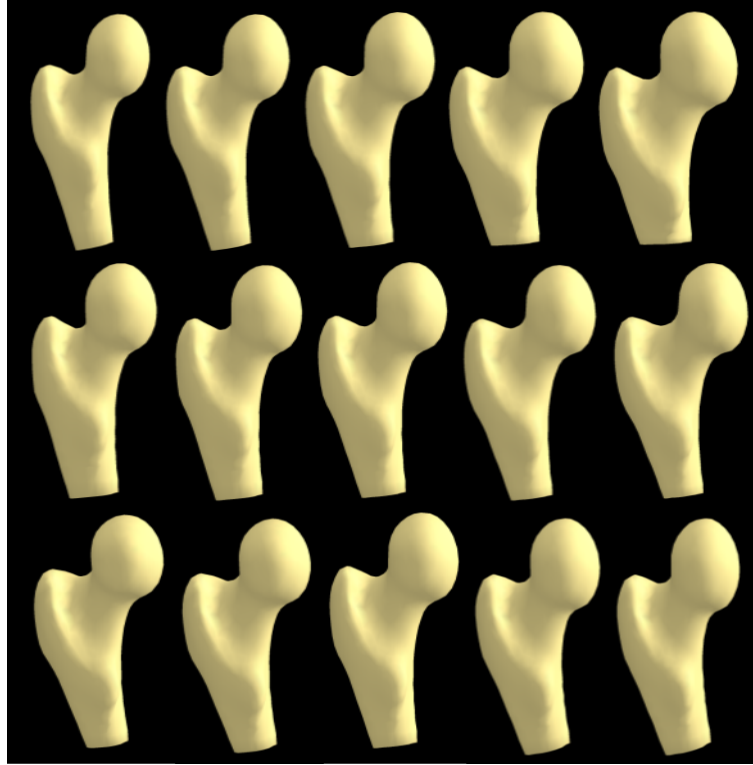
Variations in MRI-based human femur shapes by changing the shape-control parameter along the first three shape modes. The rows from the top represent shape variation due to changes in the 1st, 2nd, and 3rd major shape modes or eigenvectors. On each row, the figures represent the shape instances of mean shape varying at -3, -1, 0, 1, and 3 times eigenvalue for the corresponding eigenvector.
